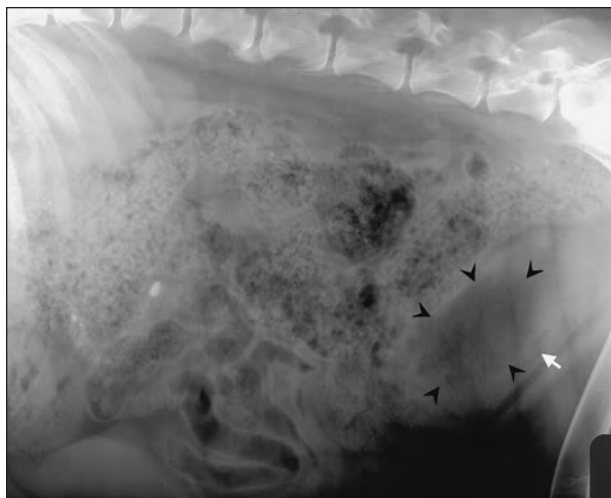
The same lateral radiographic view as in Figure 1. Air opacity is seen within the urinary bladder in the region of the lumen (arrow heads). In addition, foamy and linear air opacities are evident in the wall of the urinary bladder (arrow). Spondylosis is apparent in the mid-lumbar region of the vertebral column. Fecal material within the colon obscured the appearance of the urinary bladder on the ventrodorsal radiographic view.
